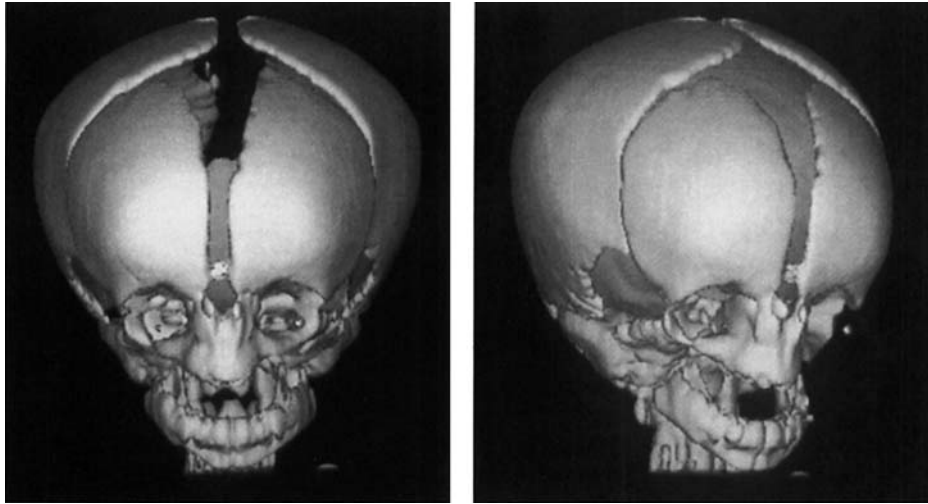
Three-dimensional, frontal (left) and oblique (right) CT images obtained at age 3 days document skeletal abnormalities. Note absent nasal passages, zygomas, and mandibular rami.
